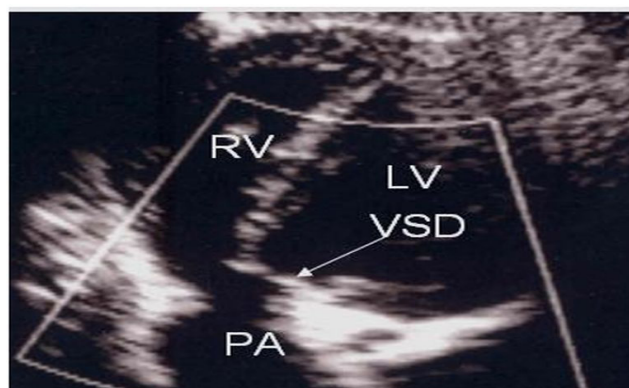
Echocardiographic appearance of the VSD
